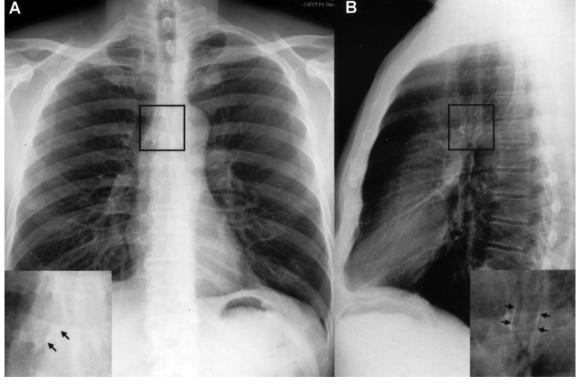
Chest radiographs. (A) Posteroanterior and (B) lateral views. The separate pictures in the corners show the magnified portions within the black frames. The very faint calcified outlines (black arrows) of the foreign body could be seen in the lower trachea and right main bronchus.
